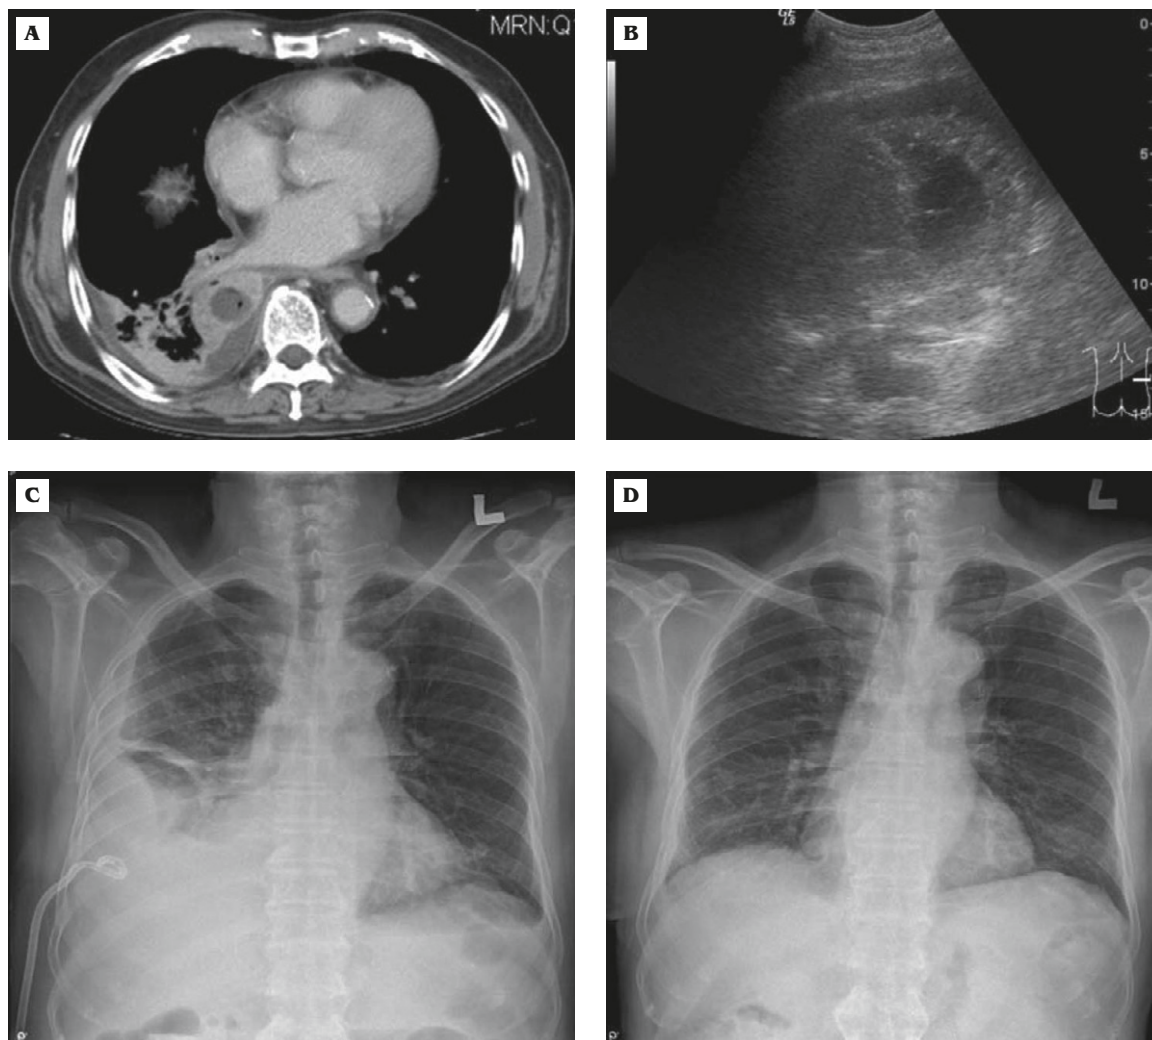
(A) Computed tomography demonstrates consolidation of the right lower lobe with multiloculated parapneumonic pleural effusion. (B) Ultrasound findings of septate fluid collections. Chest radiography shows: (C) enlarging loculated effusion with interlobar extension after pigtail catheter drainage; (D) full expansion of the right lung after chest tube removal.
